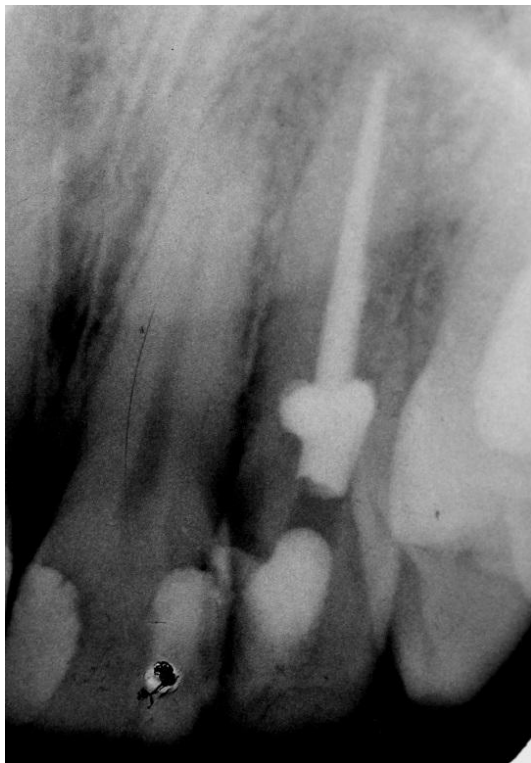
Final mesial radiograph
